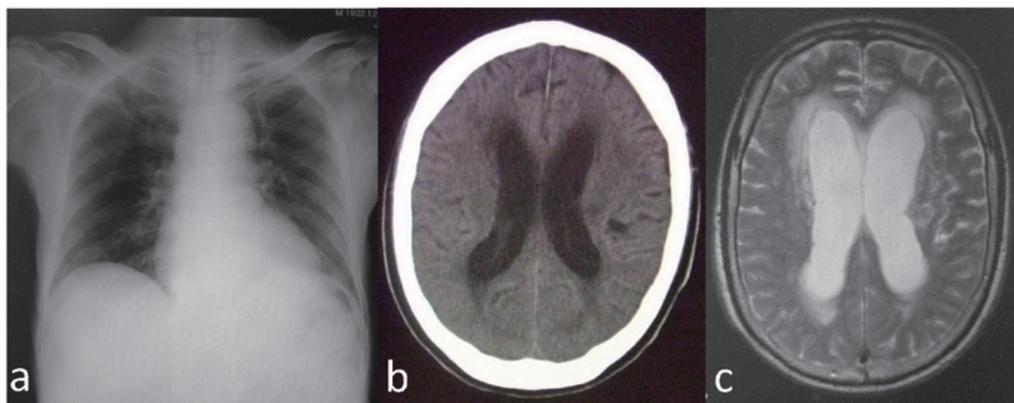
(a) Normal chest X-ray. (b) Brain CT showing slight ventricle enlargement. (c) Brain MRI showing ventricle enlargement.
